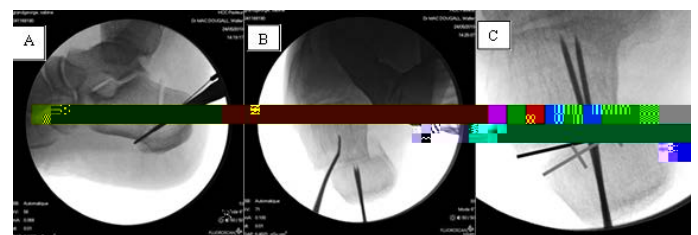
A) A Prone Radiographic View of Calcaneal Chevron Osteotomy. B) Axial View Shows Medialisation Using Lever Arm. C) Axial Radiographic View Shows Medial Translation of Not More than One Third of Calcaneal Width with Slight Internal Rotation of the Posterior Calcaneal Fragment.
